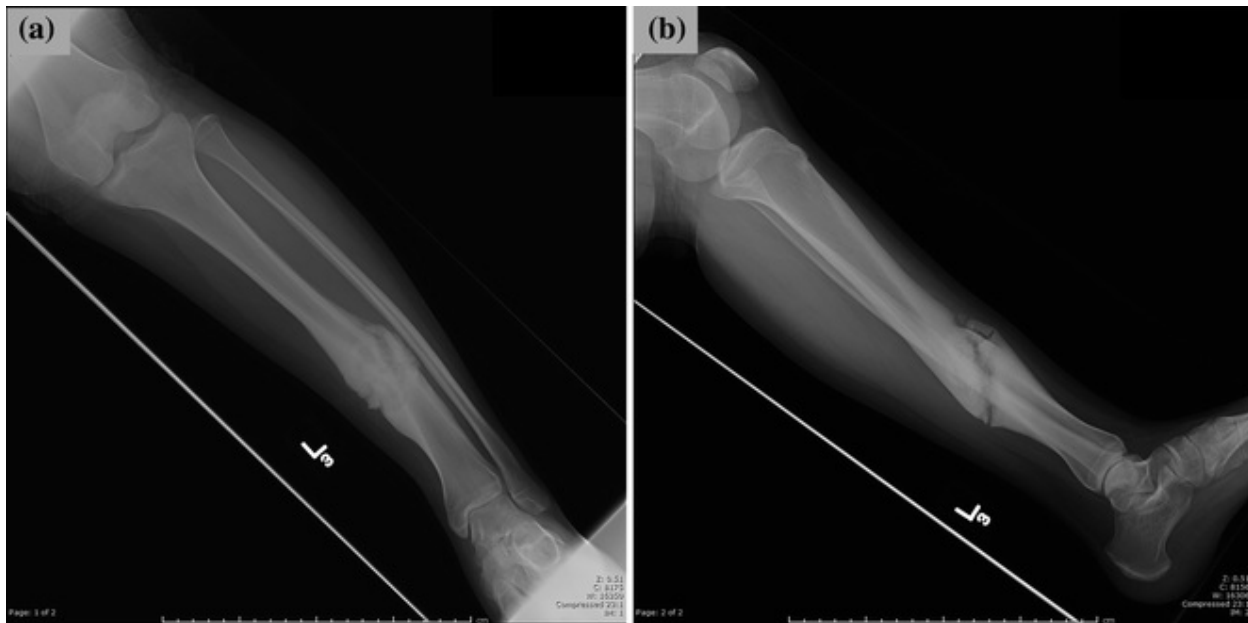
a, b Anteroposterior and lateral radiographs of a patient with a low energy left tibia fracture treated with cast immobilization that went onto a hypertrophic (“elephant foot”) nonunion
